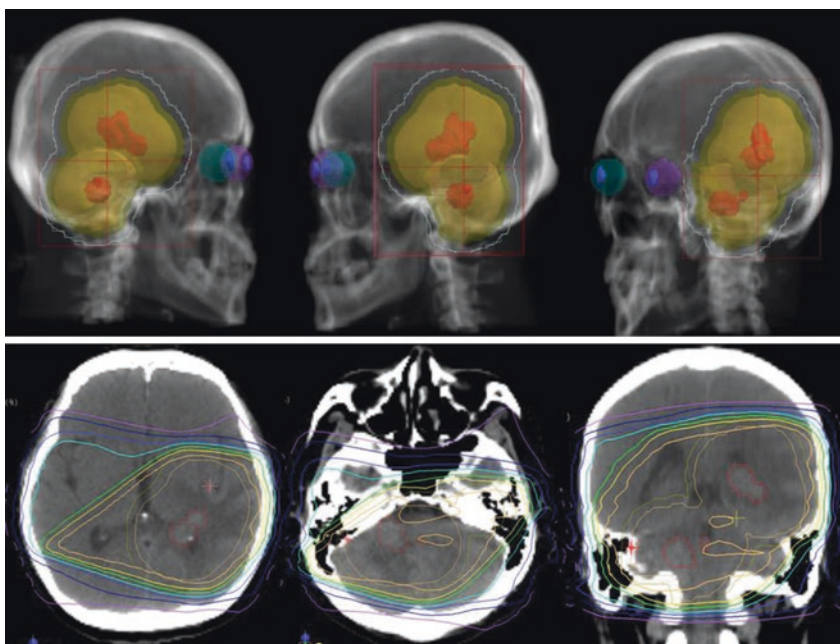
Boost radiotherapy with 3D-CRT using three portal 15 MV X-ray beams. The GTV is displayed as a Gd-enhanced area (*red*). The CTV (*orange*) and PTV (*pale yellow*) are superimposed on the beam's-eye-views (*upper panels*). The *lower panels* show the distribution in the representative planes. A total dose of 10 Gy was delivered in five fractions over the course of 1 week
